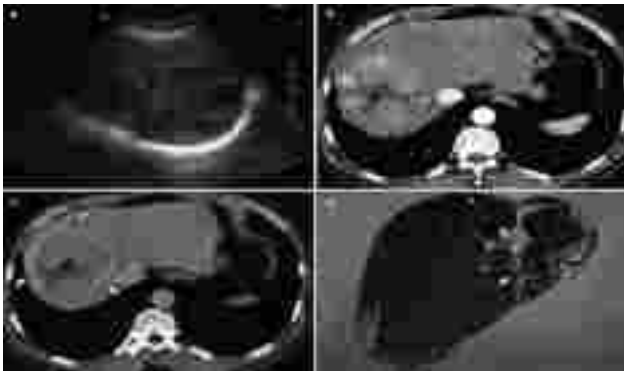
HCC. (a) nodular formation with heterogeneous hypoechoicity of the right hepatic lobe. (b) CT scan of the arterial phase shows an increase in the heterogeneous density of the tumor (arrow) with a hypoattenuated center (asterisk). (c) Venous phase CT scan shows the tumor with a thickened peripheral pseudocapsule and intratumoral necrotic area (asterisk). (d) the macroscopic appearance of the operating part. (JM Lee et al., *Imaging Findings of Cirrhotic Liver, in Multislice-CT of the abdomen*, 2012)
